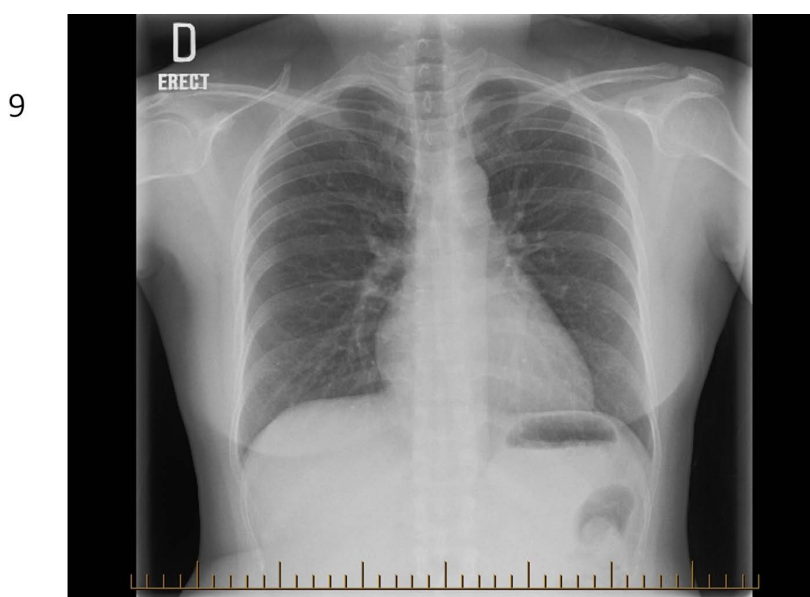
Anonymized chest radiograph. Example of an anonymized chest radiograph with a randomized identifying number, as presented in the distributed PowerPoint presentation.
